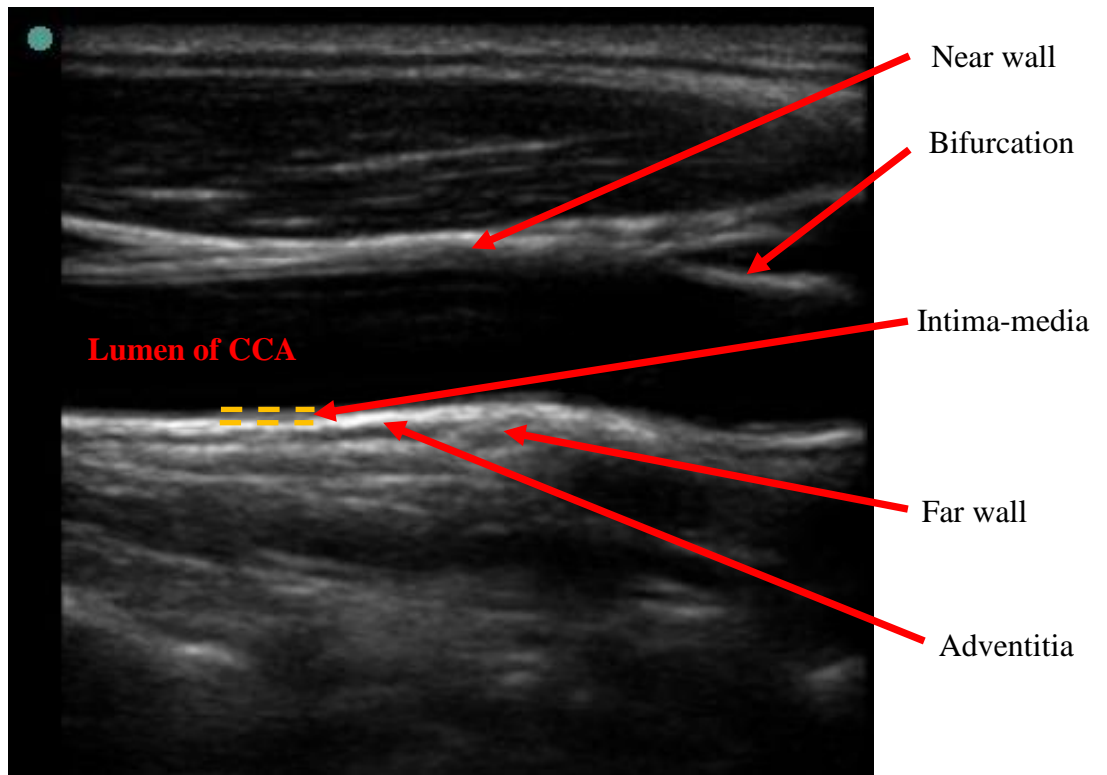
Ultrasound image of common carotid artery segment showing the lumen, near and far walls, the intima-media complex (between the dotted yellow lines) as well as the adventitia layers.
